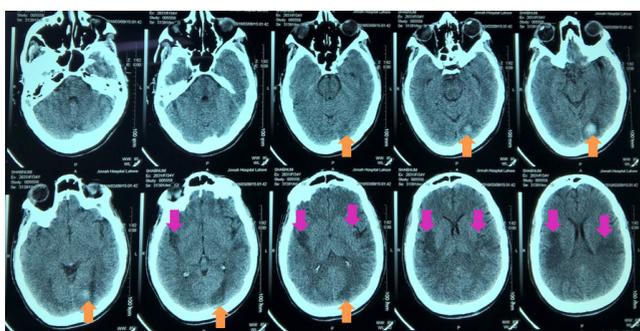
CT scan Brain of the patient
